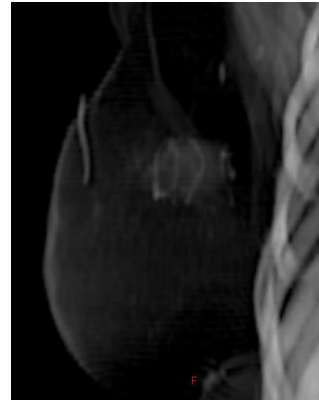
Settings to achieve optimal visualization of FM on the DRR: Gantry Rotation = 50°, Collimator Rotation = 0°, Couch Rotation = 0°, DRR parameters (Weight = 1, CT Window [HU] from 0 to 200).
